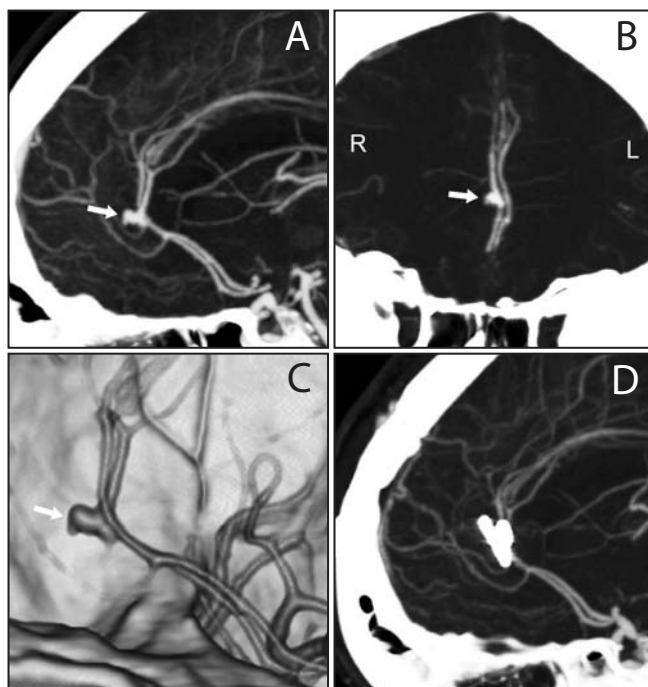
Ruptured anterior A3A (arrow) as seen on (A) preoperative sagittal CTA, (B) preoperative coronal CTA, (C) preoperative 3D CTA, and (D) postoperative CTA.
